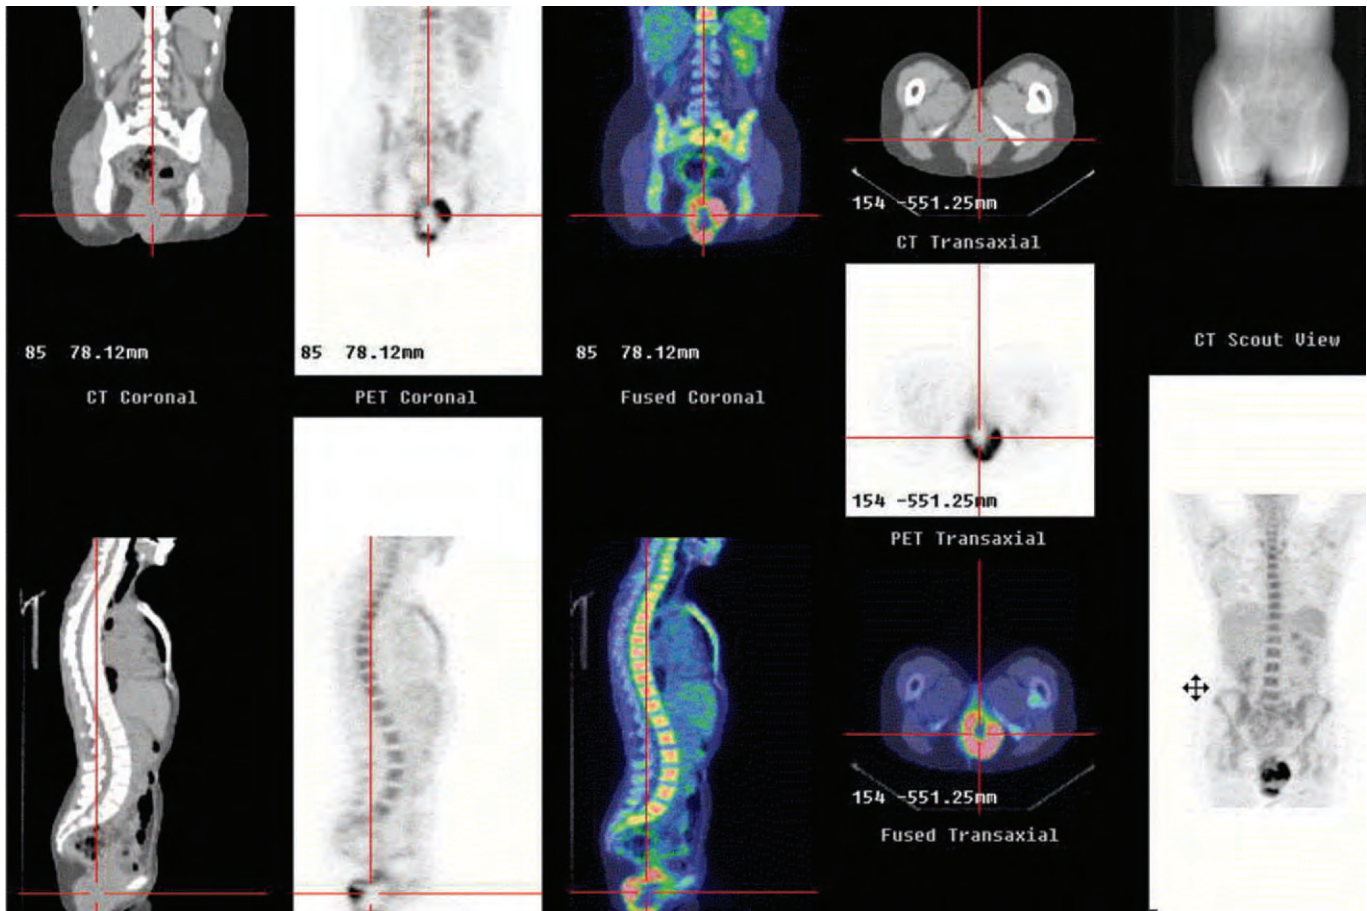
FDG PET CT fusion showing rectal leiomyosarcoma with central inactive core (likely necrosis) and no evidence of metastatic disease.
